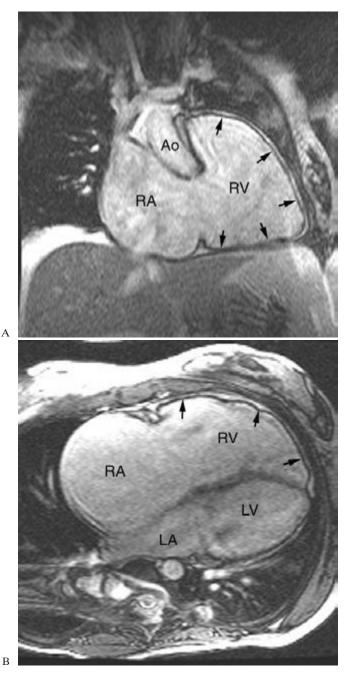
1 Uhl's anomaly of the right ventricle. Coronal (A) and axial (B) MR images show that the heart is markedly enlarged with dilatation of the right atrium (RA) and right ventricle (RV). The right ventricular free wall (arrows) is paper thin and surrounded by a thin layer of epicardial fat. Ao, aorta; LA, left atriium; LV, left ventricle.
